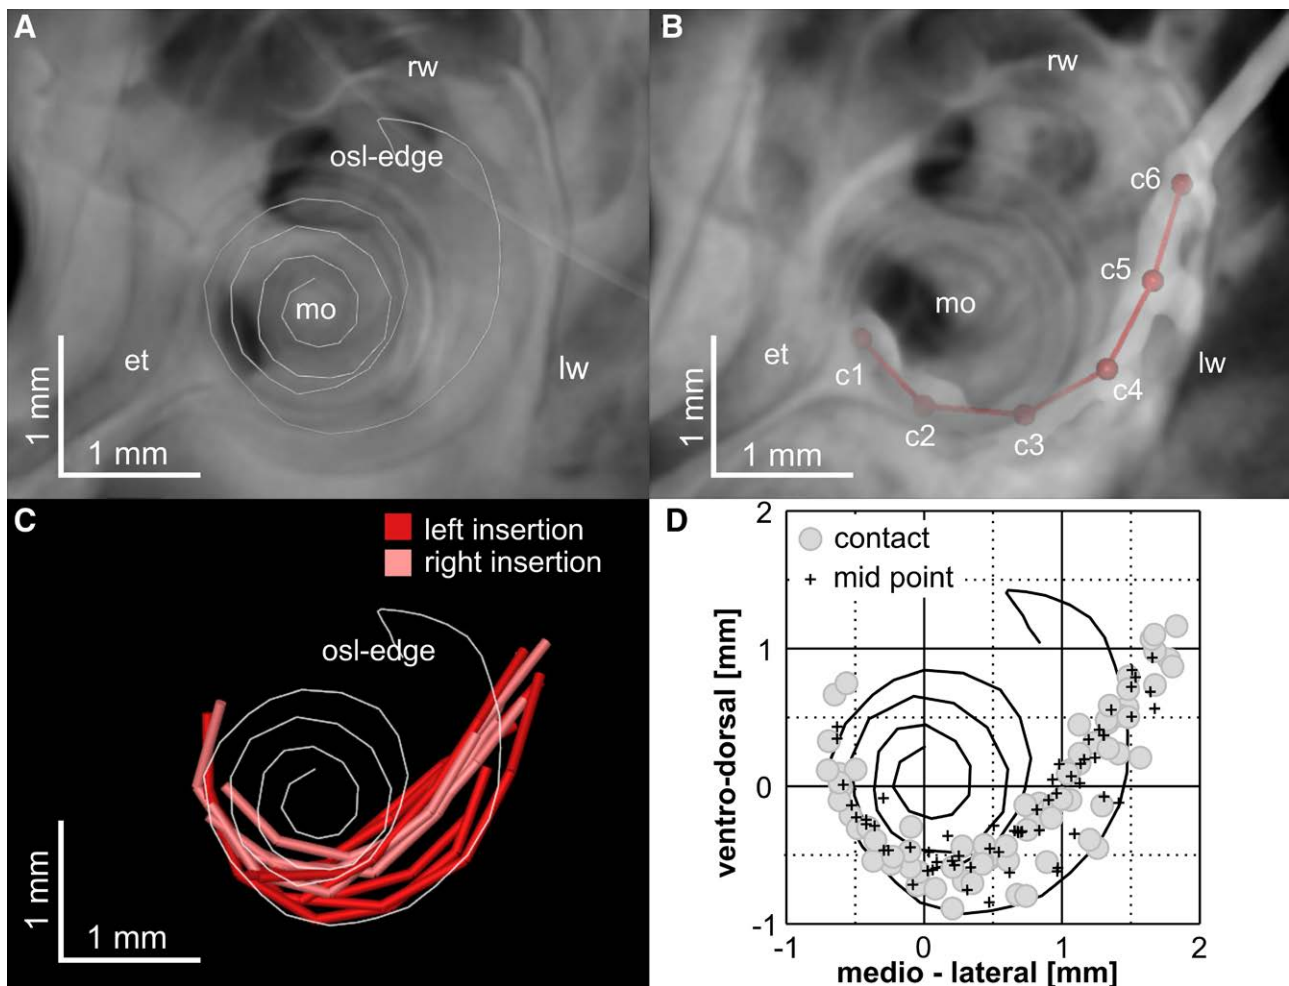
Validation of the functional data using anatomical cochlear reconstruction. A, First, the length of the cochlea was estimated along the edge of the osseous spiral lamina (osl) in micro computed tomographic (μ CT) images of a non-implanted left template cochlea. B, Second, an implanted study case was registered onto the template cochlea. Image stacks of right cochleae were mirrored before registration. Markers were placed onto the CI contacts (c1, c2, ..., c6). C, For all 13 study cases the contact positions (not shown) and insertion paths were three dimensionally related to the template osl length. The insertion depths and angles were then determined. D, To obtain an estimate of the bipolar recording positions ($n = 61$), the midpoints between neighboring contacts were calculated. For a full insertion this reconstruction resulted in 5 midpoint positions. The corresponding frequency information was calculated according to the reconstructions by Tsuiji and Liberman (1997). CI indicates cochlear implant; et, Eustachian tube; lw, lateral wall of the basal turn; mo, modiolus; osl, osseous spiral lamina; rw, round window.
